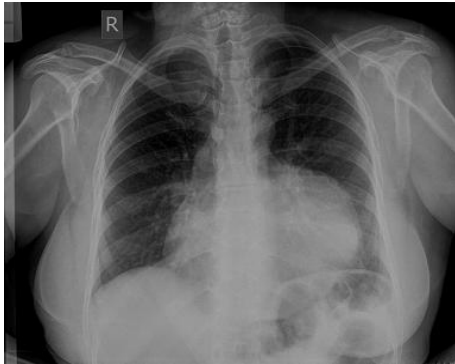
Anteroposterior chest radiographies showing cardiomegaly and external bulging of the left heart silhouette.
